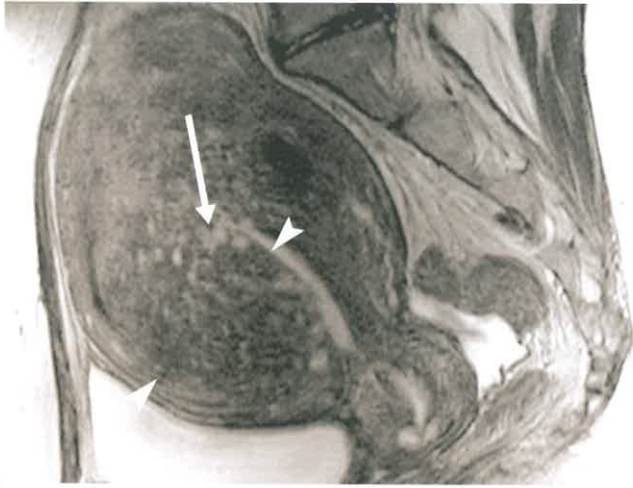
Adenomyosis. T2-weighted sagittal plane MR image shows marked widening of the junctional zone myometrium (between arrowheads), a key finding of adenomyosis. Tiny cystic deposits of endometrium seen as high signal intensity round foci (arrow) within the fibrotic lesion are also characteristic.
